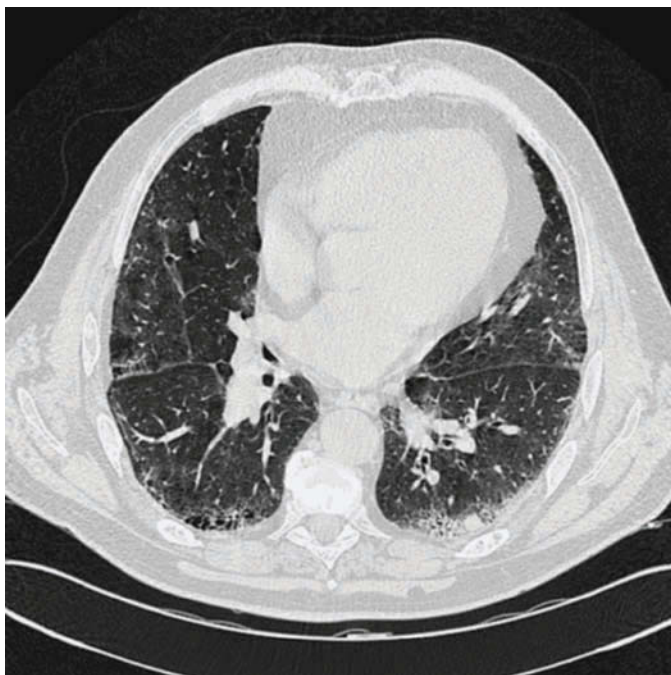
Computed tomography scan showing areas of ground-glass attenuation and small subpleural cystic images in the base of the right lower lobe, for a differential diagnosis of either emphysema or honeycombing.
